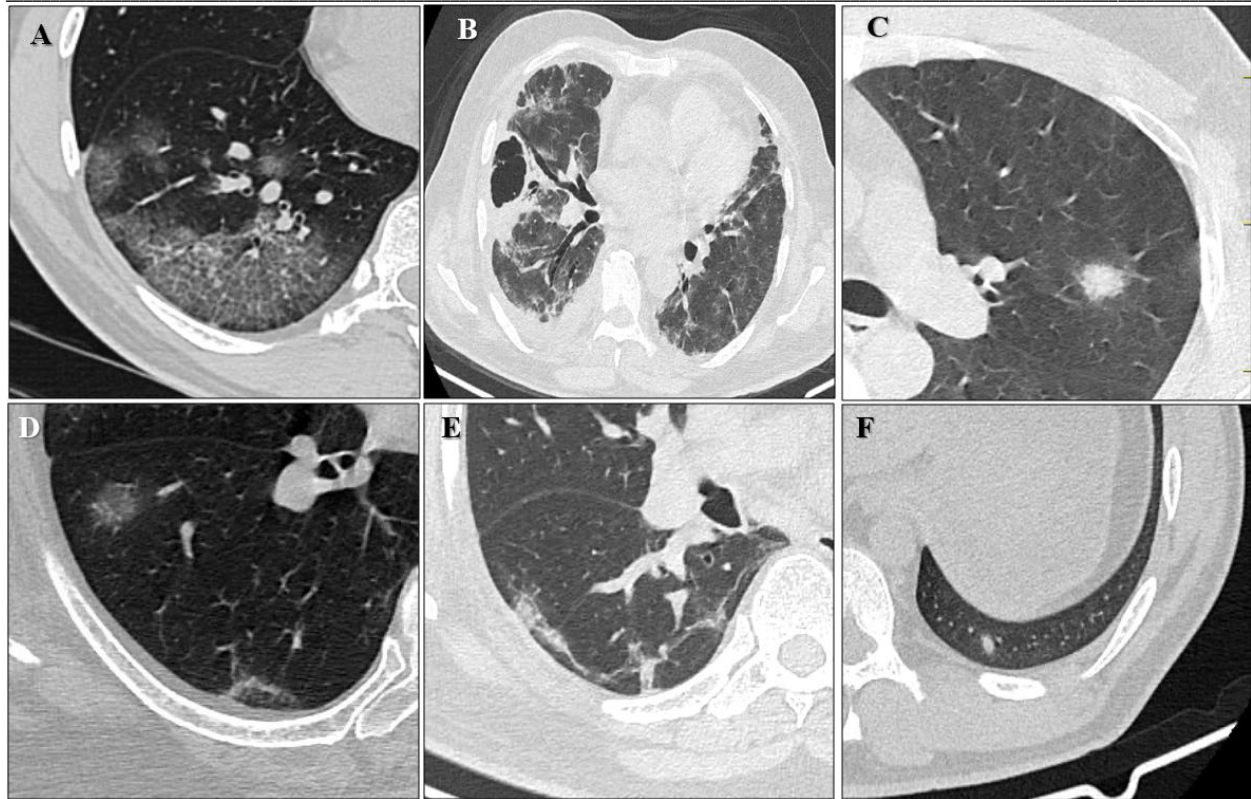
Axial section through HRCT reveals (A) patchy peripheral GGO with crazy paving in right lower lobe, (B) diffuse GGO with a cavitary lesion with surrounding consolidation in the lateral segment of right middle lobe, (C) rounded consolidation with surrounding GGO (Halo sign) in superior lingular segment, (D) rounded GGO in the anterobasal segment of right lower lobe, (E) subpleural curvilinear band-like opacities in the superior segment of right lower lobe and (F) subpleural GGO nodule in the posterobasal segment of left lower lobe
